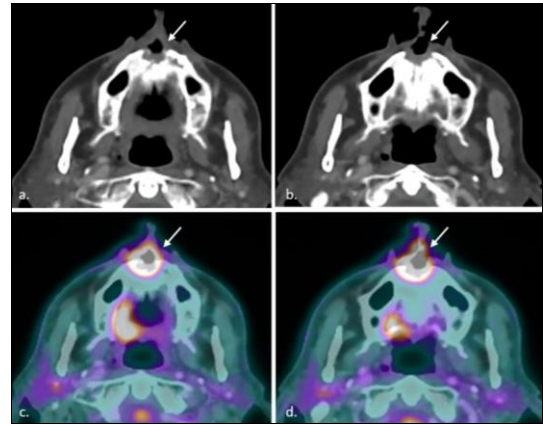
Contrast enhanced CT and PET/CT with 2-[18F] FDG. Axial images demonstrate minimal peripheral enhancement (a and b) and intense radiopharmaceutical uptake (c and d), indicating a hypermetabolic lesion with a SULmax of 7.8
